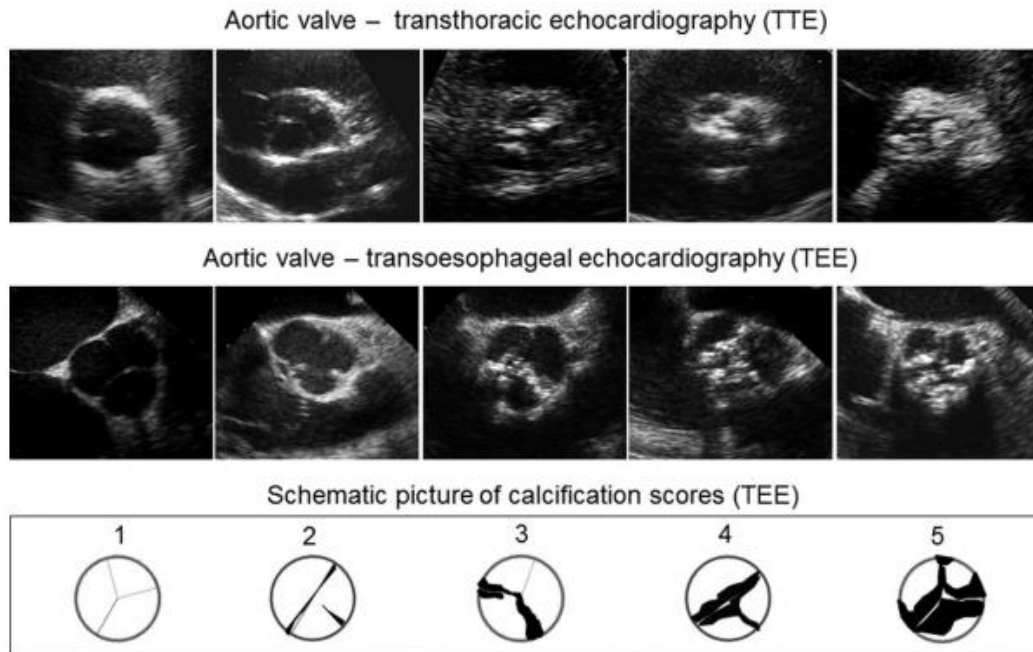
Representative images of echocardiographic examination of different grades of aortic valve stenosis. Transthoracic (TTE, upper panel) and transoesophageal (TEE, lower panel) echocardiographic scoring of aortic valve calcification and relative pictures of calcium deposition. Image from Yousry M. et al. Aortic valve type and calcification as assessed by transthoracic and transoesophageal echocardiography.
